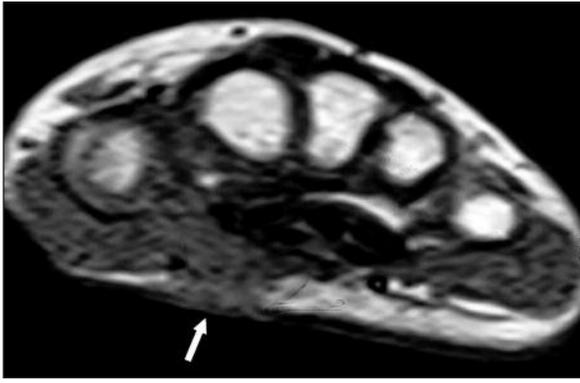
The lesion (arrow) has decreased signal intensity similar to that of skeletal muscle in T1-weighted images.
